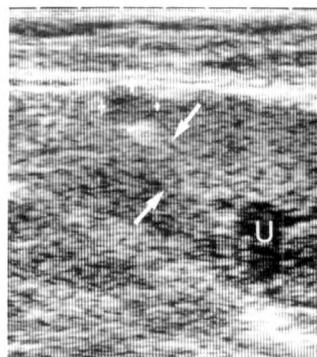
Sonogram shows solitary low-echo lesion (cursors) in the subcapsular area of the liver. Small hepatocellular carcinoma was strongly suspected and fine-needle aspiration was carried out three times. Even though an echogenic structure suggesting fibrotic changes (arrows) of umbilical vein was recognized, vessel communication between the umbilical portion of the left portal vein (U) and this lesion was not shown.
